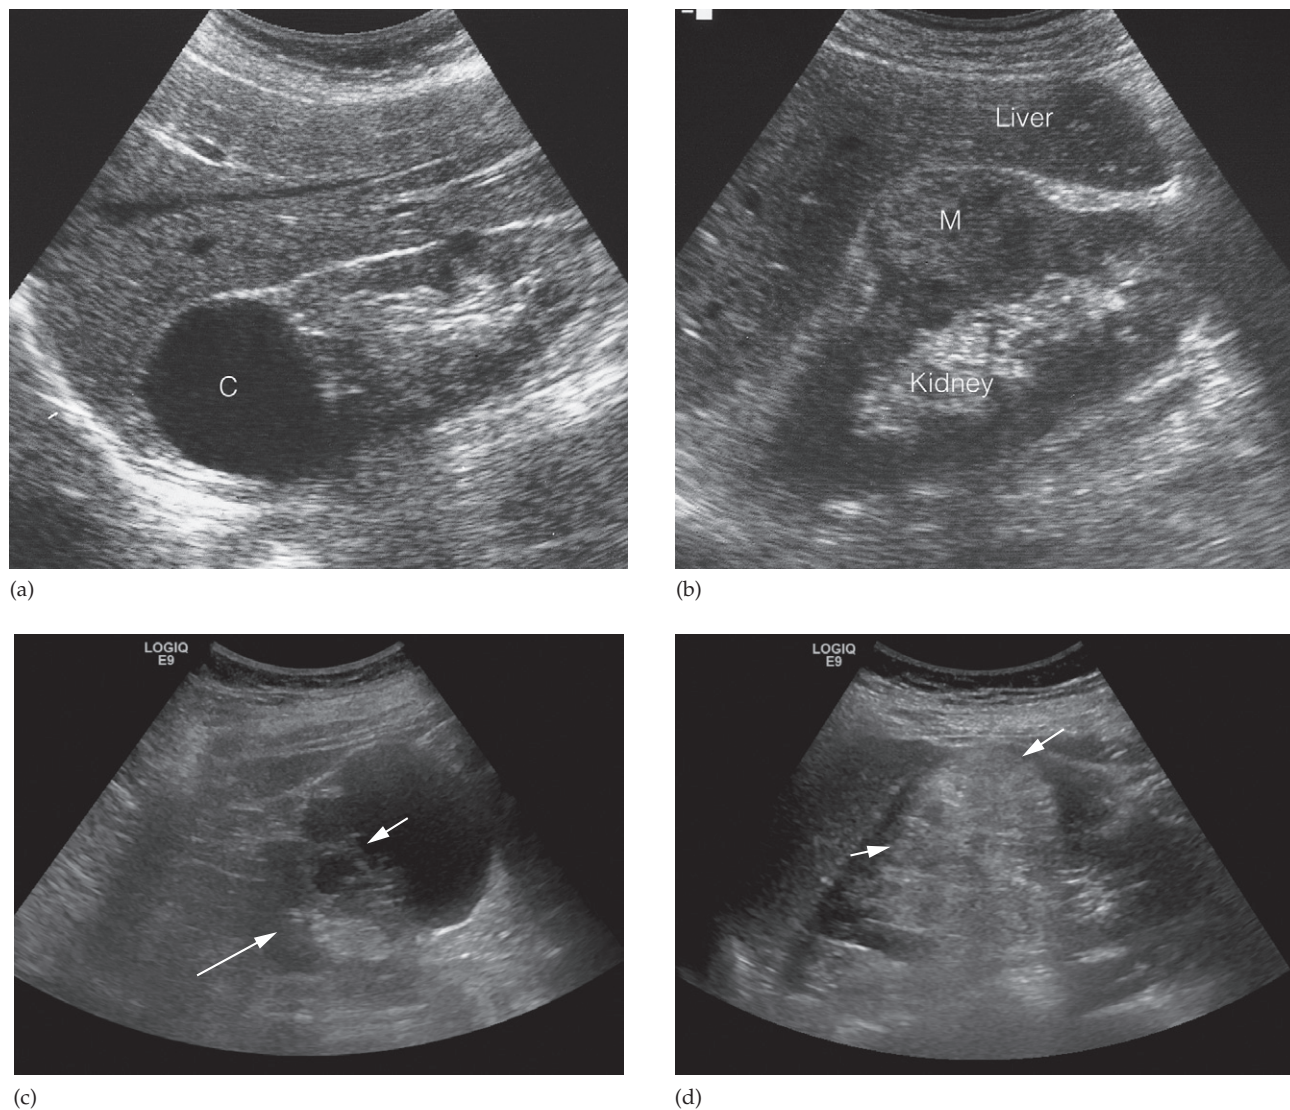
Ultrasound in renal masses. (a) Simple cyst (C) showing sharp walls and no echoes arising within the cyst. Note the acoustic enhancement behind the cyst. (b) Tumour showing echoes within a solid mass (M). (c) Complex cystic mass which could be due to cystic renal cell carcinoma. The short arrow points to the irregular solid part of the mass. The adjacent normal renal parenchyma is shown with a long arrow. (d) Angiomyolipoma; this incidental finding shows the typical appearance of a well-defined echogenic mass (arrows). Same patient as in Fig. 8.32c.
